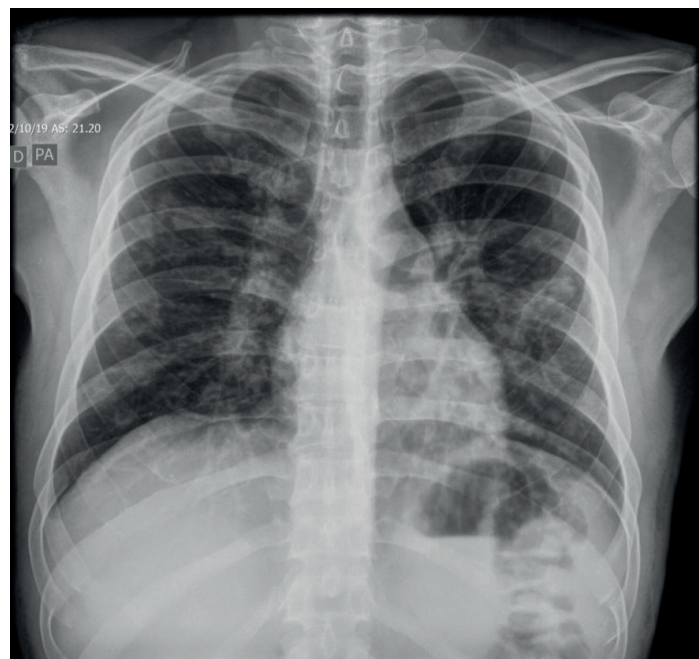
Chest radiography, posteroanterior and lateral views.
